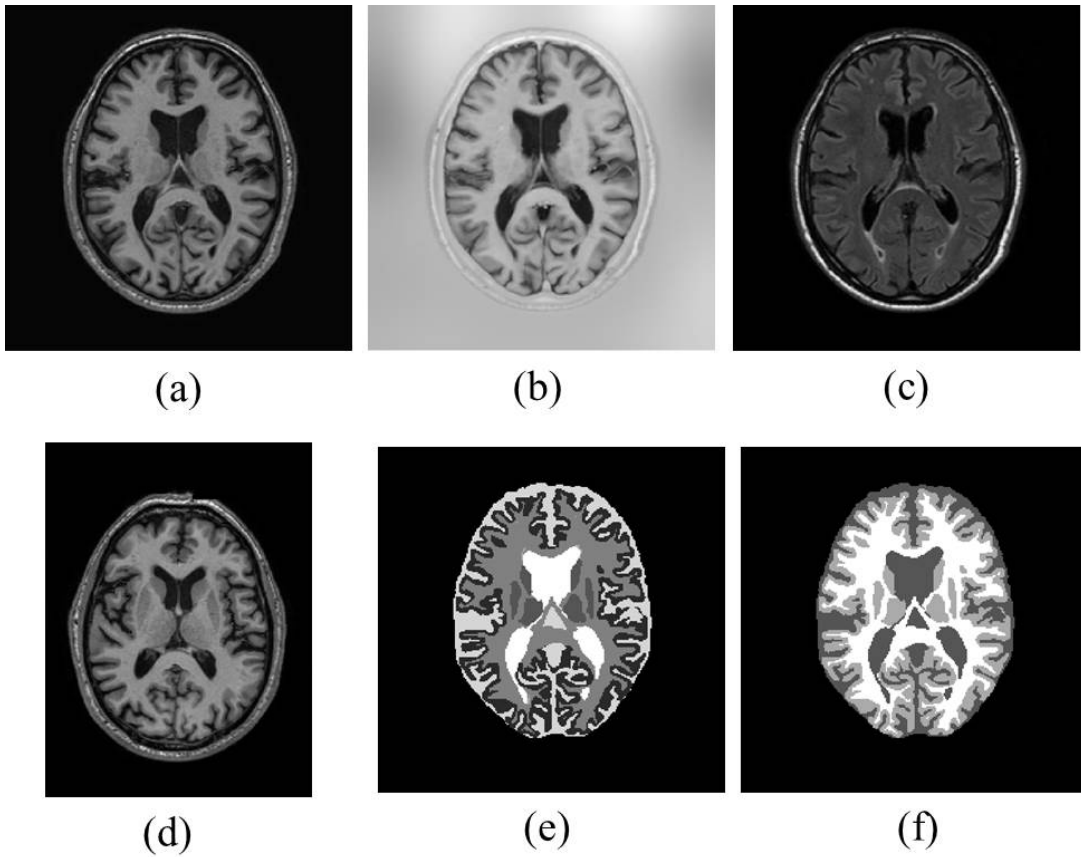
Multi-sequence axial slices of brain volumes in training sets of MICCAI2013. Images are T1-w (a), T1-w IR (b) and FLAIR (c) slices; high-resolution T1-w image (d); manual segmentations of structures (e) and tissues (f), respectively.
